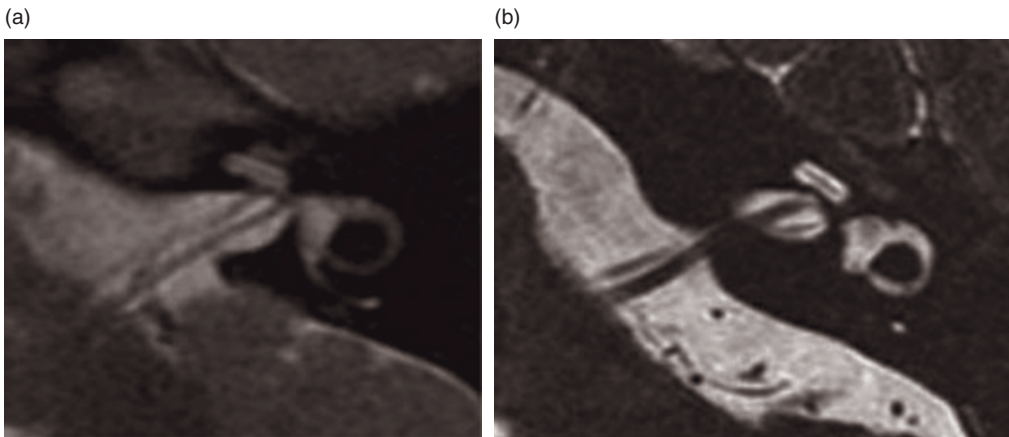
T2-weighted MR axial images at 1.0 T (a) and 3.0 T (b): the representation of the inner ear and nerves is clearly improved at 3.0 T (courtesy of S. Battaglia and M. Leonardi, Neuroradiology Bellaria Hospital, Bologna, Italy).
